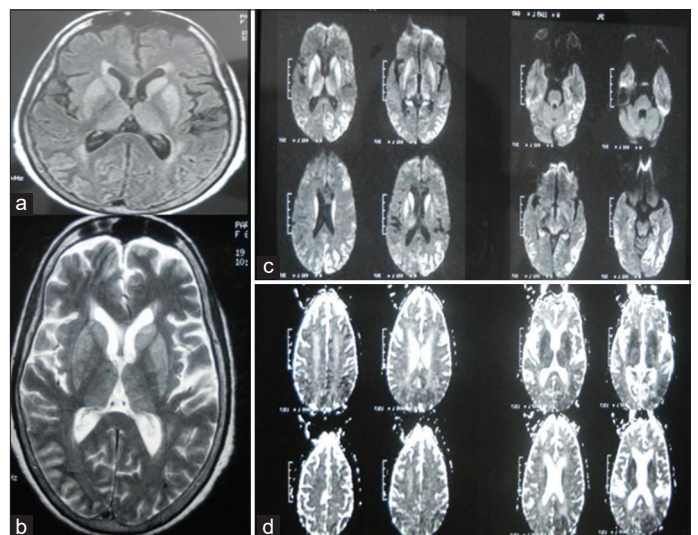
(a) Magnetic resonance imaging (Cranium) on T2 fluid-attenuated inversion recovery displayed hyperintensities in bilateral basal ganglia, (b) and (c) diffusion-weighted imaging revealed gyriform hyperintensities in the bilateral frontal and parietal region (cortical ribboning), and (d) apparent diffusion coefficient exhibited reduced signals in gyriiform cortex (case 2)
